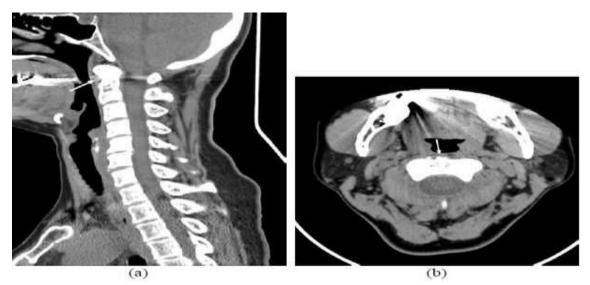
Follow-up Neck CT. a. sagittal view. b. transverse view. Both of them reveal markedly decreased amount of calcification (arrow) at longus colli tendon deposition
